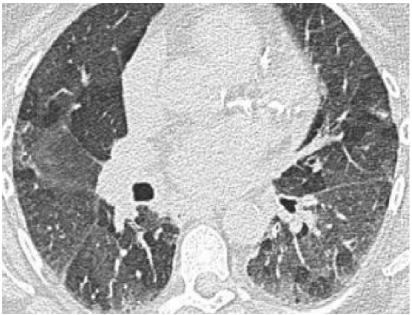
Chest CT scan (high resolution) in inspiration, millimeter section. heterogeneous ground glass areas: hypersensitivity pneumonitis related to mold exposure.
